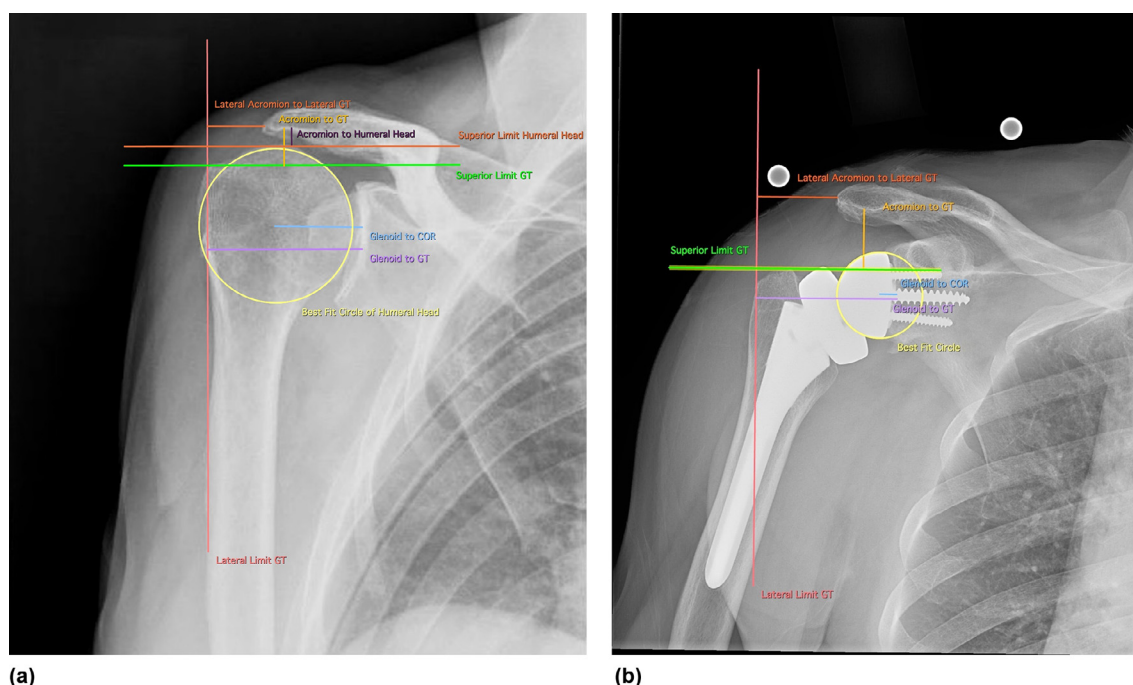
Measurements performed on preoperative radiographs (a) and at most recent follow-up (b).
